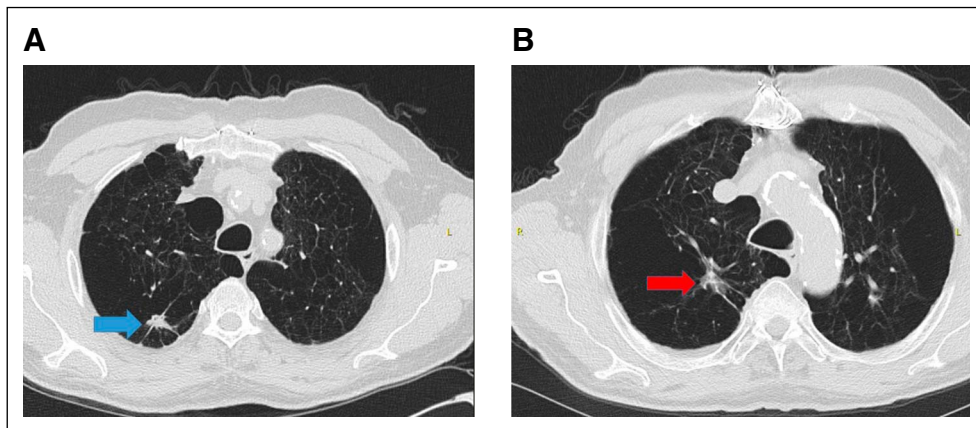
Case of a 72-year-old male with medically inoperable (by severely impaired pulmonary function), American Joint Committee on Cancer, 8th edition, T1aNOMO stage IA1 adenocarcinoma of the RUL of the lung, enrolled in the RPCI-124407 trial, randomly assigned to 60 Gy in three fractions completed on March 2012. (A) Representative pretreatment computed tomography axial slice of January 2012 demonstrating RUL lung cancer (blue arrow). (B) Representative computed tomography axial slice of April 2022 demonstrating stable fibrotic response in treated RUL lung cancer 10 years after SBRT (red arrow). RPCI, Roswell Park Cancer Institute; RUL, right upper lobe.
